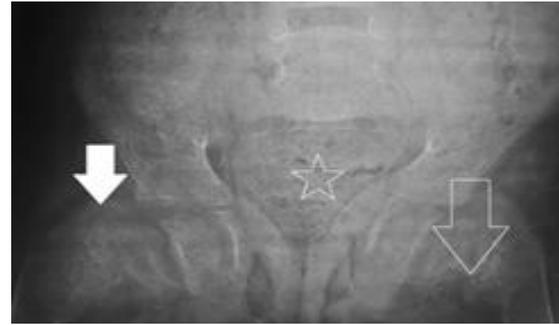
X-Ray Pelvis anteroposterior view. There is osteopenia and pseudo-fracture (hollow arrow) with dislocated right femoral head (solid white arrow). Pelvis shows triradiate deformity (white star).
